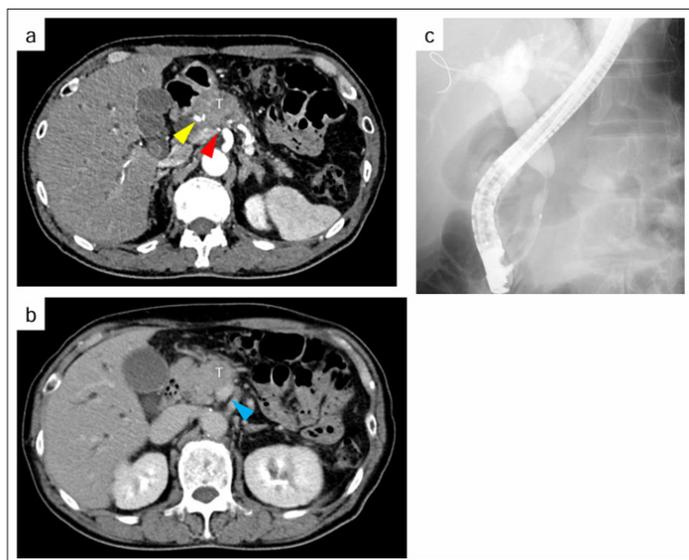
Dynamic computed tomography and endoscopic retrograde cholangiopancreatography at initial diagnosis. T: tumor; red arrowhead: CHA; yellow arrowhead: PHA; blue arrowhead: PV.
